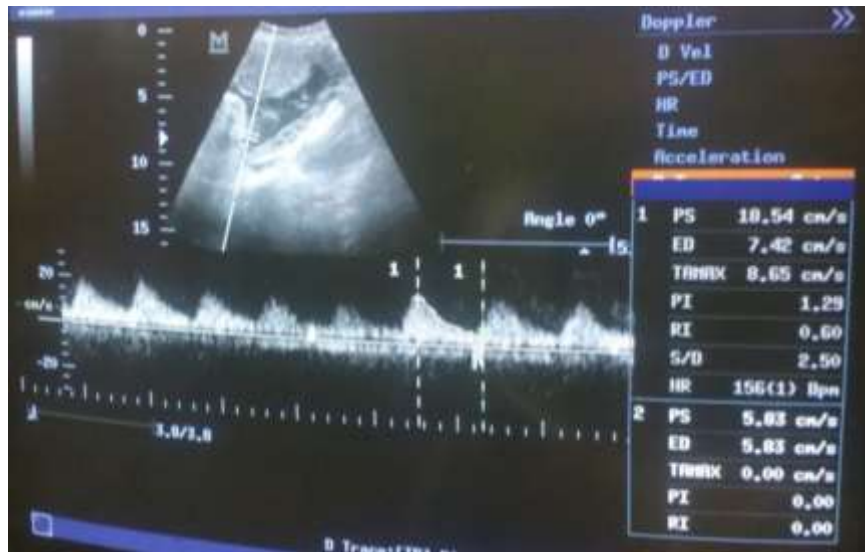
a) shows color Doppler umbilical artery waveform at 35 WKs
